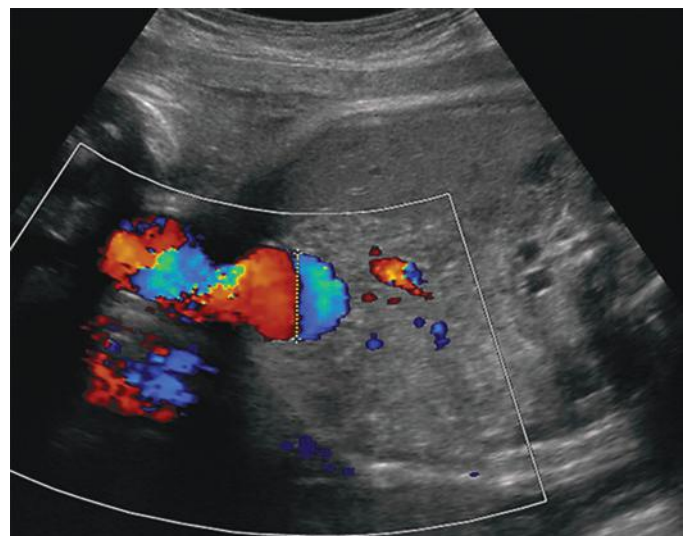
Umbilical vein varix. Color Doppler sonography depicts focal enlargement of the intra-abdominal umbilical vein in this 36-week gestation. The diameter of the vein measured 17 mm.
